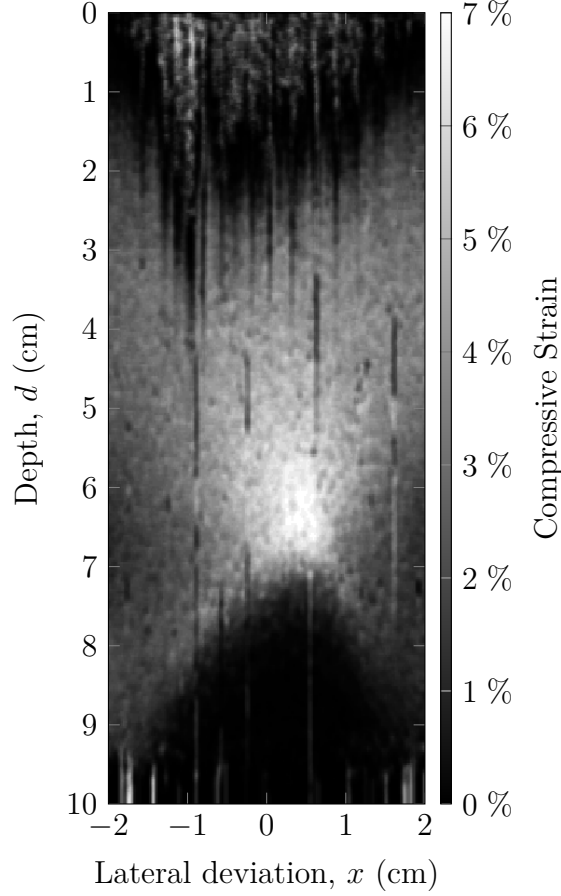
Elastogram for a 0.5 cm wide lesion embedded in the Visible Human-MRI model domain at a depth of 7.25 cm interrogated at 4 MHz with an applied strain of 2.5 %. The lesion is not visible and is the resultant elastogram.
